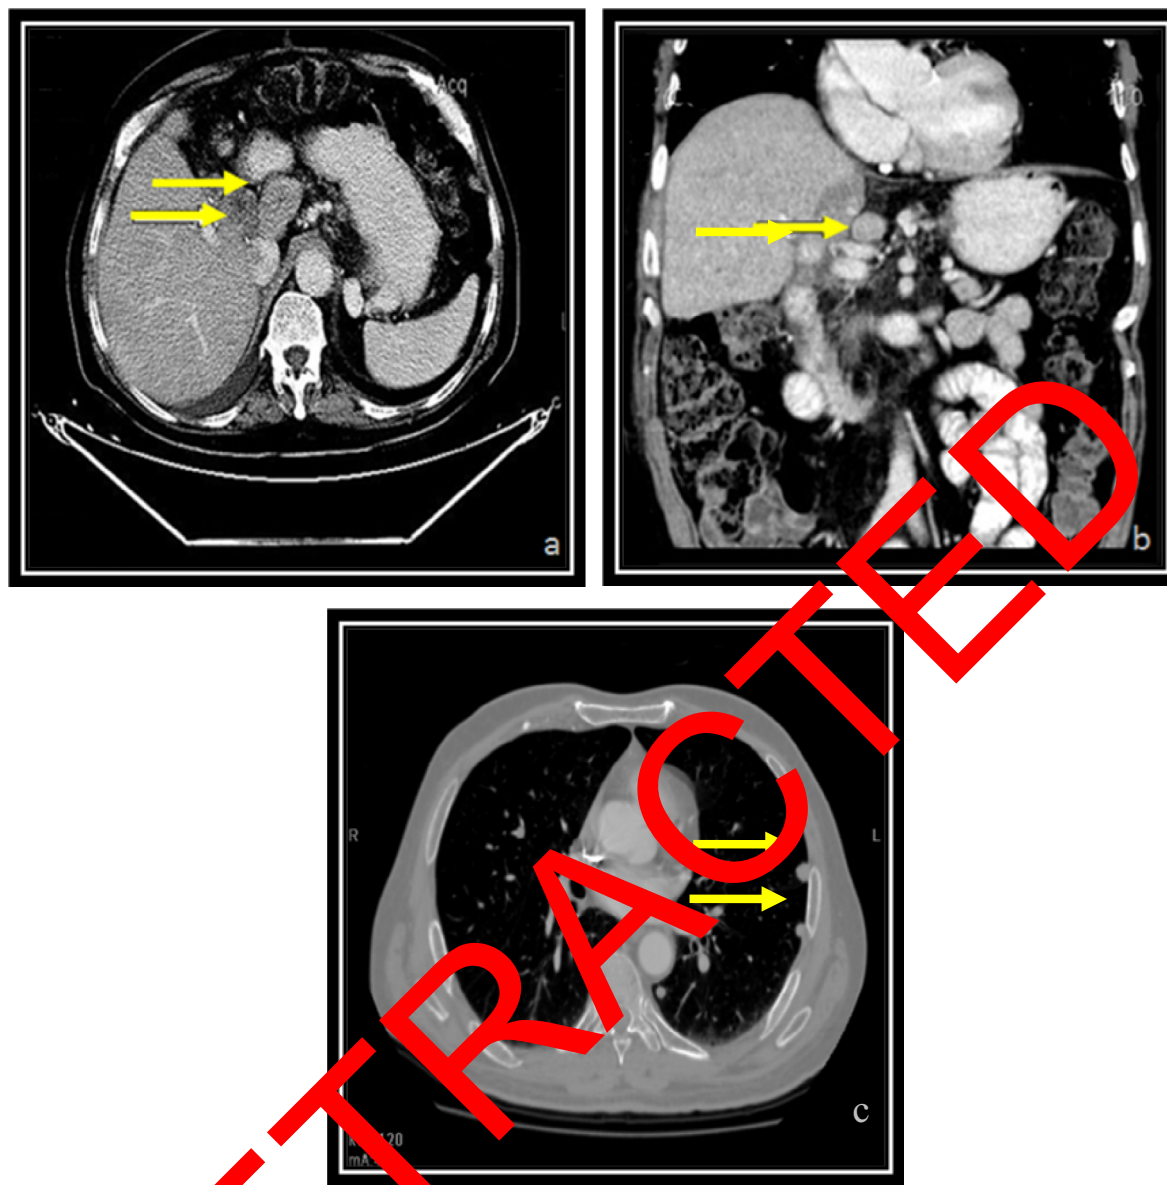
Axial arterial MDCT image shows two lymph nodes with peripherally enhancing wall and necrotic center at the porta-hepatis (arrows in a). Coronal reformatted images showing the lymph node (arrows in b). Axial CT chest cuts show multiple lung nodules, some being sub-pleural in location (arrows in c).
